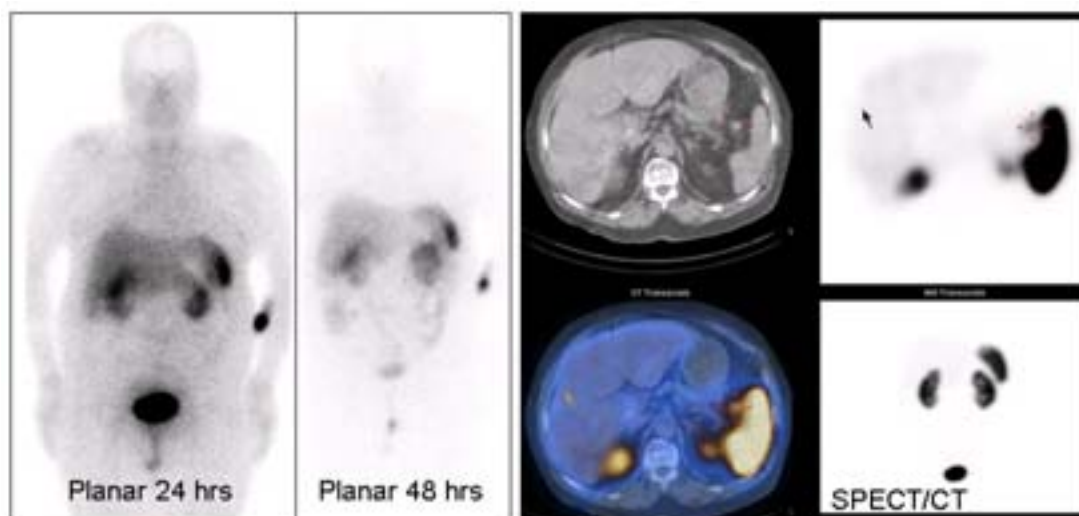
^{111}In -octreotide SPECT/CT in pancreatic insulinoma. A 68 year old woman was hospitalized because of severe hypoglycemia. CT indicated a suspicious lesion in the tail of the pancreas. Whole body planar scans performed at 24 and 48 h after tracer injection are normal. SPECT demonstrates a small focus of abnormal tracer activity in the left upper abdomen, in close proximity to the high ^{111}In -octreotide uptake in the spleen. This suspicious lesion is localized by SPECT/CT fused images to the small lesion seen on CT in the tail of the pancreas, consistent with a pancreatic insulinoma. No additional sites of abnormal tracer activity are seen. The patient was referred for surgery.
